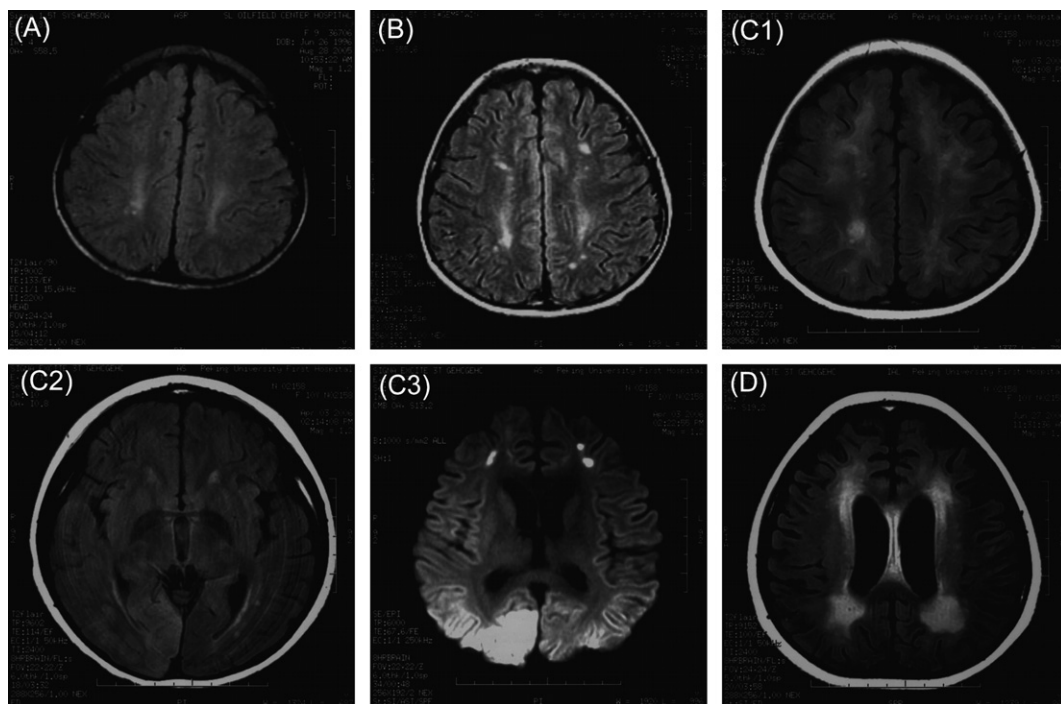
Magnetic resonance image of the brain. (A and B) Flair image of brain MRIs in 2 days and in 3 months of the onset of the disease showing increased signaling in white matter. (C1) Flair image of brain MRI 7 months later showing the abnormal signal in white matter was more extensive. (C2) Flair image of brain MRI showing increased signaling in right occipital region. (C3) DWI of brain MRI showing increased signaling in both occipital regions. (D) Flair image of brain MRI 10 months later showing diffuse brain atrophy, and the abnormal signal in white matter was further extensive.
